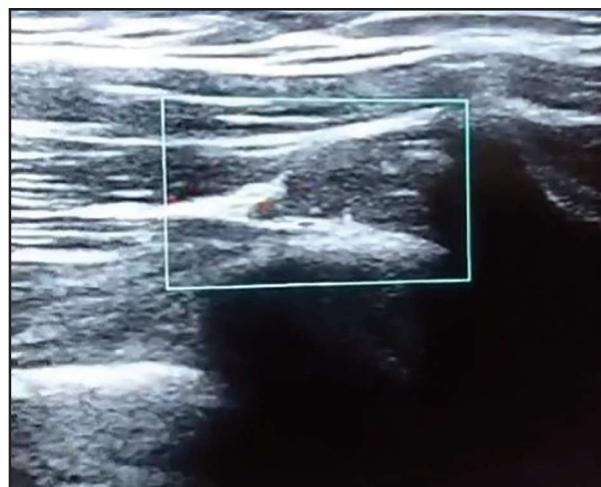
Ultrasound image at the level of the scapular spine
